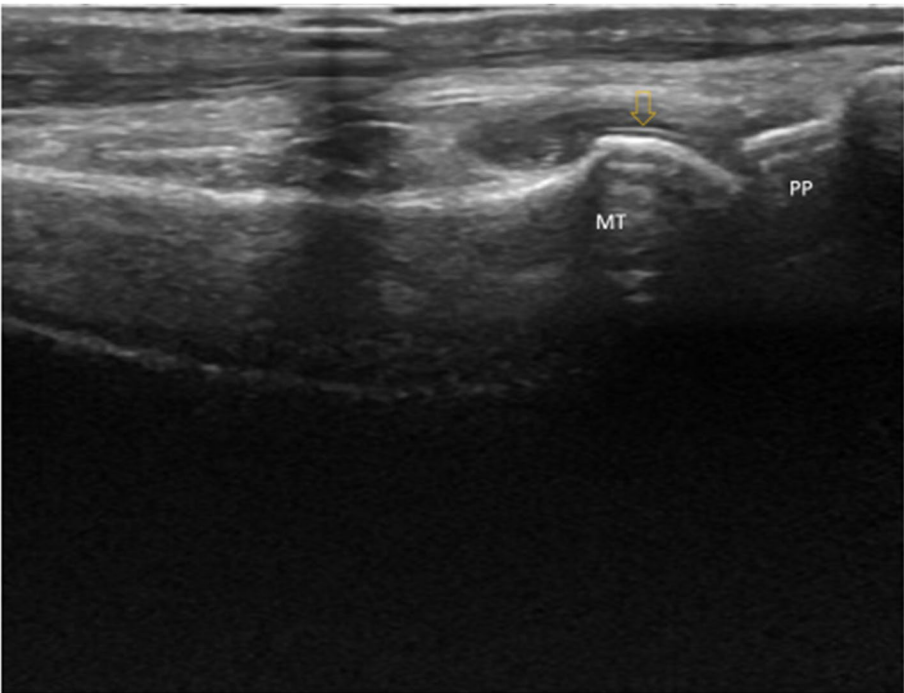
Dorsal longitudinal gray scale ultrasound scan of the 1st MTP joint showing double contour (arrow)
